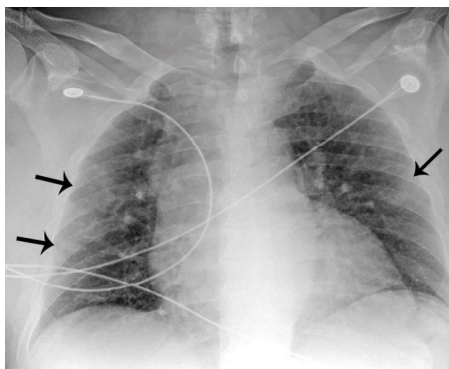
Frontal chest radiograph of a 60-year-old man with a 5-day history of cough and fever. There are bilateral opacities with lower lung predominance: consolidation in the right lower lung (curved arrow) while more subtle opacities are seen in other regions (straight arrows). There are no pleural effusions
